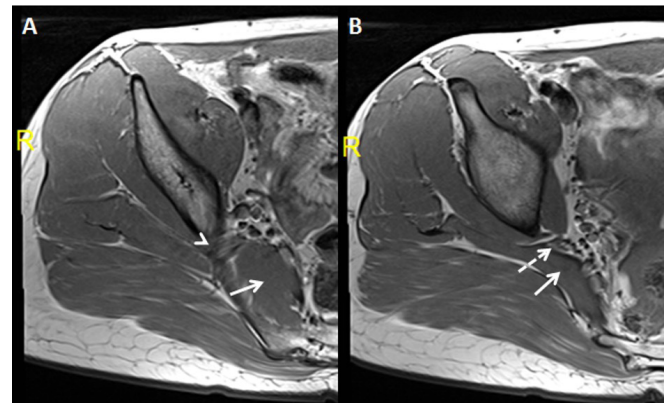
Axial T1-weighted MRI images of type 3 sciatic nerve. Solid white arrows: piriformis muscle; white arrowhead: the common peroneal component passing posterior/above the piriformis muscle; dashed white arrow: tibial component passing anterior/below the piriformis muscle.
